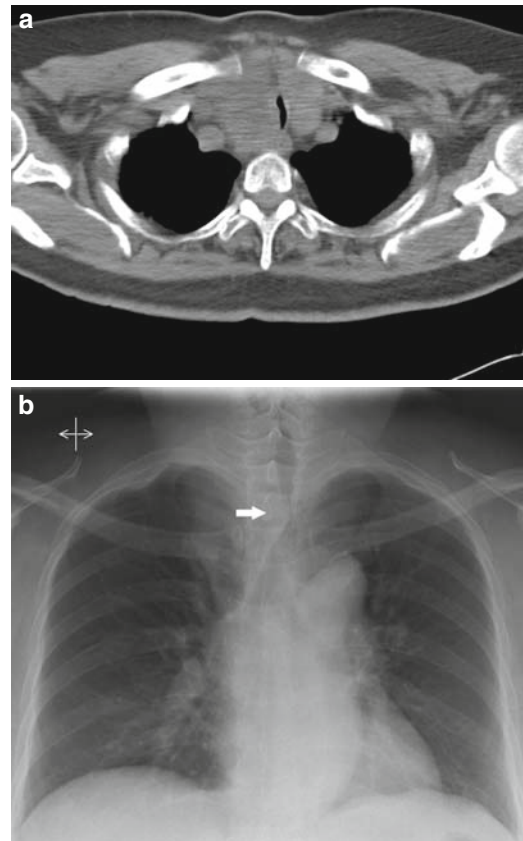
(A) Cross-sectional computed tomography appearance of undifferentiated thyroid cancer arising within a longstanding multinodular goiter in a 58-year-old female. The patient presented with acute airway compromise and distress. Invasion and compression of the trachea and esophagus are demonstrated. (B) Chest radiograph of the patient showing compression and deviation of the trachea (arrow).
